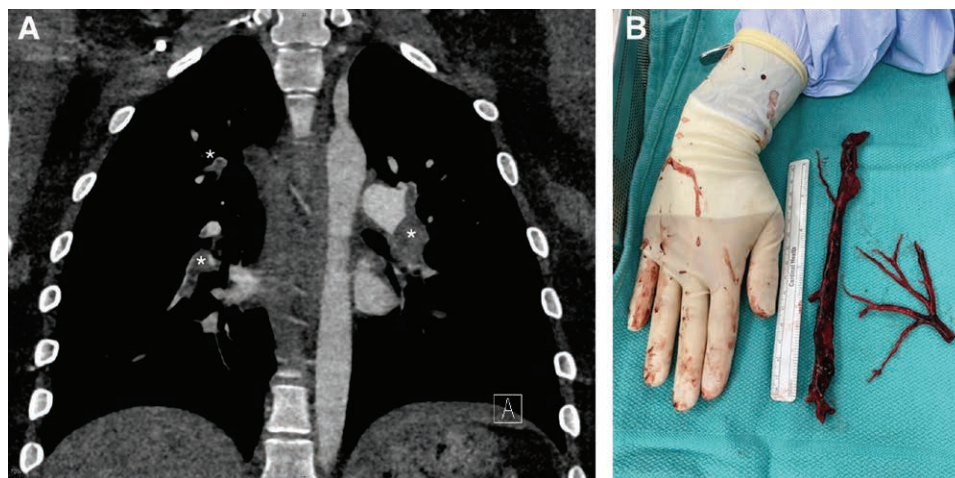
Imaging obtained during patient course. A: Coronal view of admission CT angiography for Case Report 1 through the distal branch pulmonary arteries. Significant embolism burden noted bilaterally marked by asterisk (*). B: Image of pulmonary embolism removed from patient in Case Report 2, surgeon's hand and ruler to provide scale.
